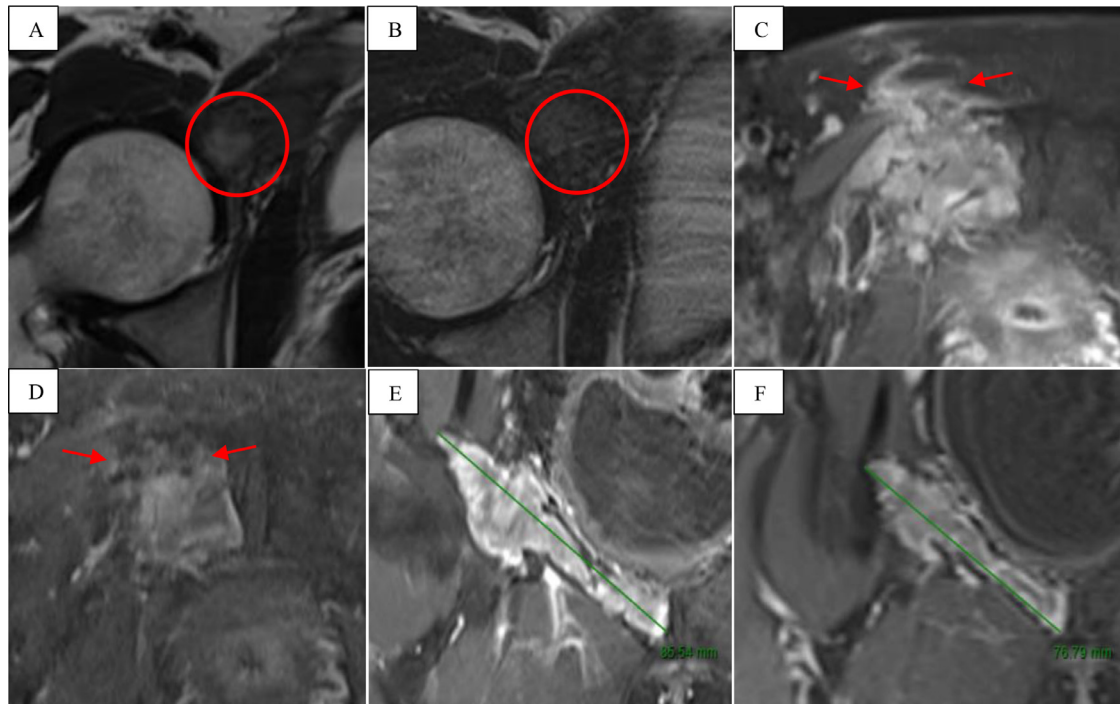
MRI images obtained for postinterventional evaluation at 8 months. The lesion’s maximal diameter exhibited a reduction of 10.2% (E: preprocedure, F: 8 months follow-up), accompanied by decreased signal intensity on T2-weighted imaging (circle, A: preprocedure, B: 8 months follow-up) and reduced contrast enhancement compared to preinterventional assessments (C and D). Furthermore, there was an absence of soft tissue component postintervention (arrows).
